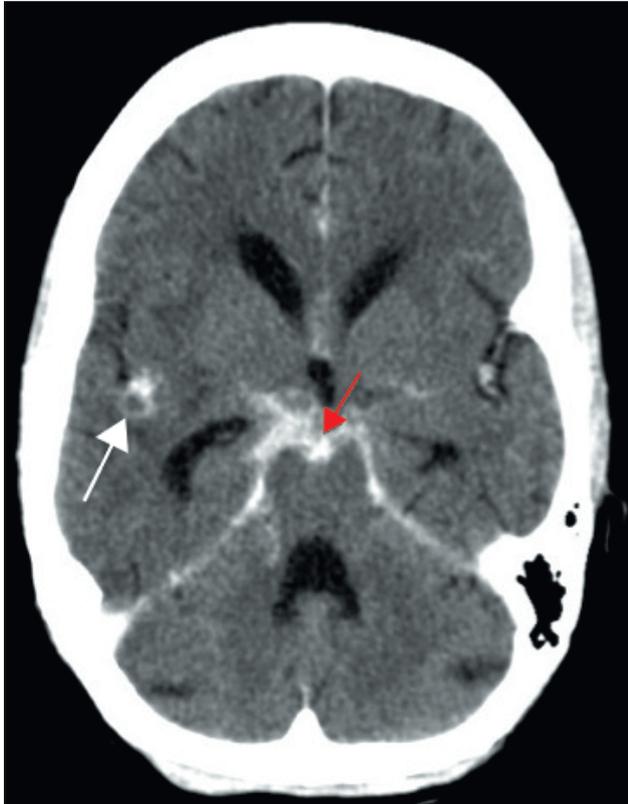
Computed tomogram of a patient with tuberculous meningitis (TBM). This contrast-enhanced axial image shows three typical features of TBM, including tuberculoma (white arrow), basal meningeal enhancement (red arrow) and hydrocephalus.
